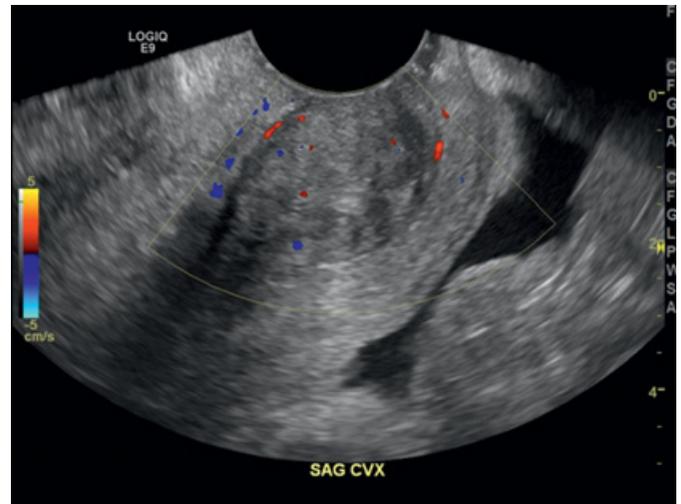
Ultrasound of submucosal leiomyoma prolapsed into endocervical canal.
